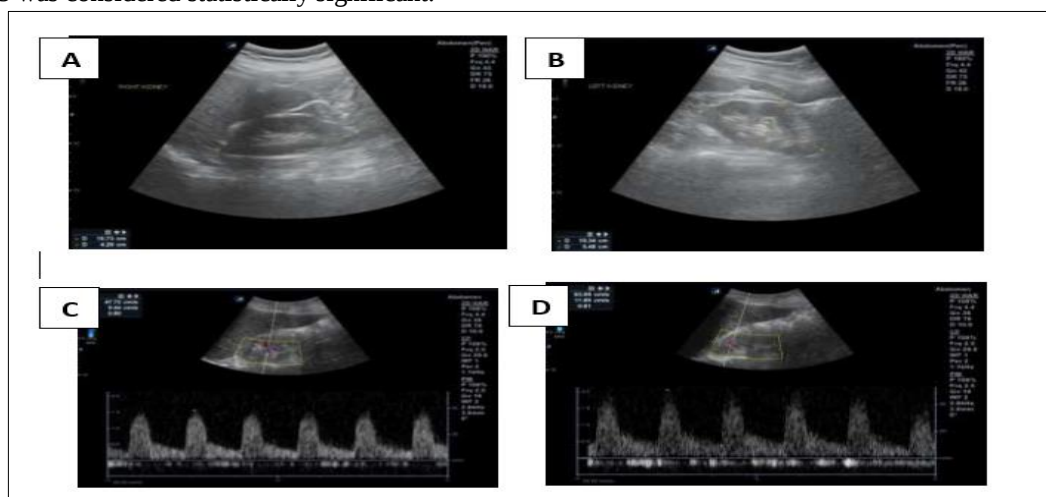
Renal ultrasonography and Doppler findings in a 56-year-old woman with a 9-year history of diabetes mellitus. (A) B-mode image of the right kidney measuring 8.6×3.7 cm. (B) B-mode image of the left kidney measuring 8.6×3.7 cm. (C) Colour Doppler imaging of the right renal segmental artery showing a resistive index (RI) of 0.80. (D) Colour Doppler imaging of the left renal segmental artery showing an RI of 0.81. The mean bilateral intrarenal RI was 0.805, exceeding the conventional upper threshold of 0.70.
